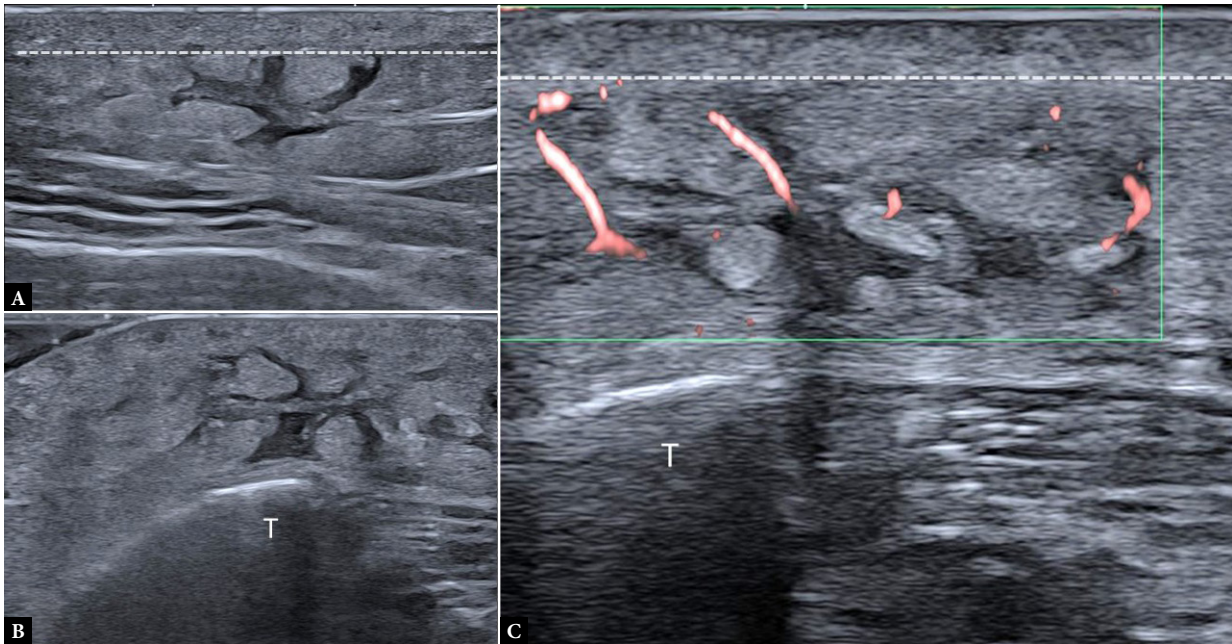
Erythema nodosum: A, B. Long- and short-axis sonograms showing a non-circumscribed area of increased echogenicity in the pretibial subcutaneous tissue, with thickened hypoechoic septa and indistinct dermo-hypodermal junction C. Hypervascularity with vessels following the septal anatomy
